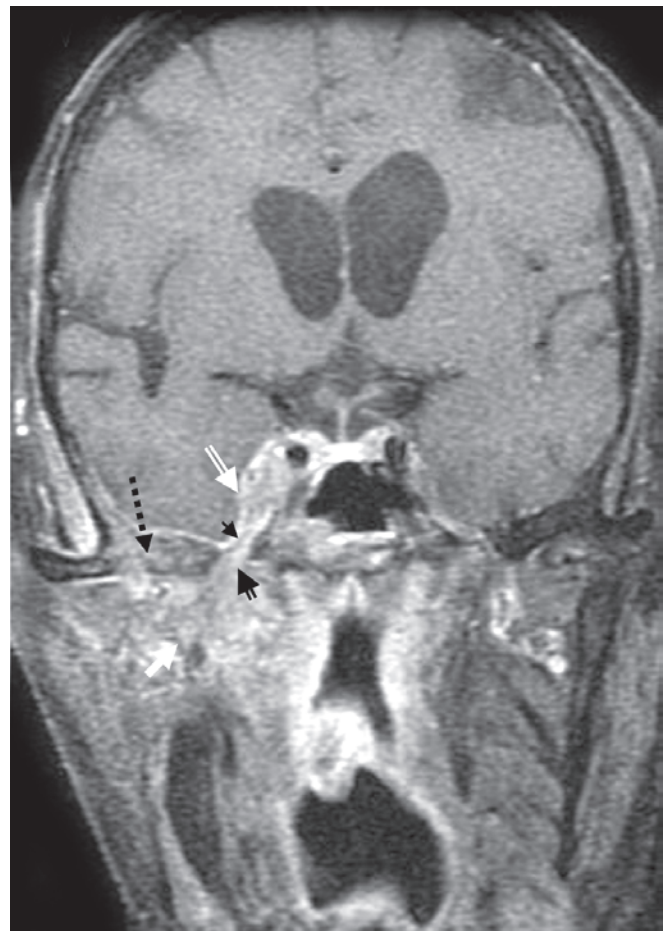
Coronal, T1 weighted, fat suppressed, contrast enhanced MR image shows an abnormal enhancement of the diploe of floor of middle cranial fossa (dashed black arrow) on right side with associated soft tissue component in the infratemporal fossa (white arrow). Extension of soft tissue is seen via the foramen ovale (open black arrow) with enlargement and enhancement of the trigeminal nerve in the region of the Meckel's cave (small black arrow). Cavernous sinus is involved (open white arrow). This patient is a known case of carcinoma oropharynx with skull base metastases with perineural spread. He presented with right sided trigeminal neuralgia and ptosis
